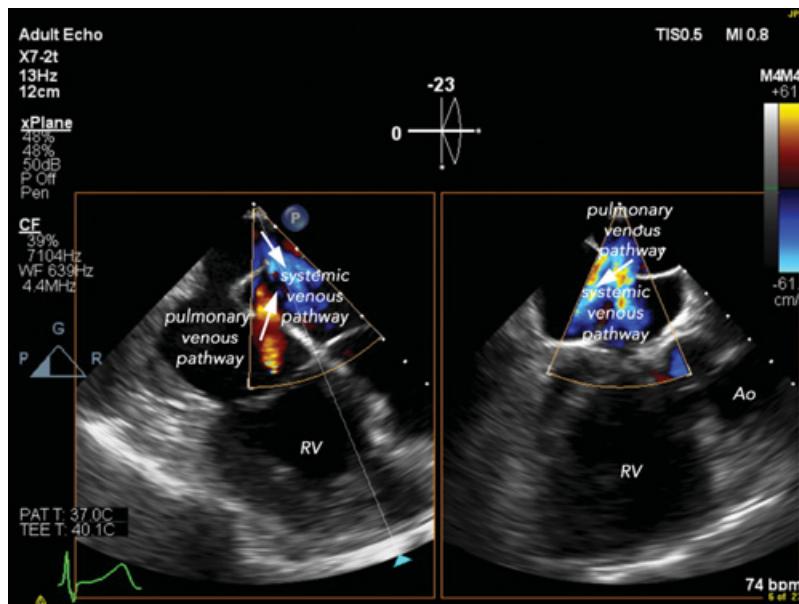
A TEE color flow Doppler ME four-chamber view and an orthogonal cut at the level of the posterior leak. This is easily performed using a TEE probe capable of biplane (X-plane) imaging. Both leaks are seen in the left-sided image, and the direction of flow is left-to-right (arrows). Although the dimensions are not measured in these images, they are quite large and measure at least 1 cm in this plane (based on the dots on the side of the image which are 1 cm apart). The right-sided image cuts through the more leftward and posterior defect only (see blue triangle at the bottom of the image and the location of the cutting plane). Ao, aorta; CFD, color flow Doppler; ME, mid-esophageal; RV, right ventricle.
